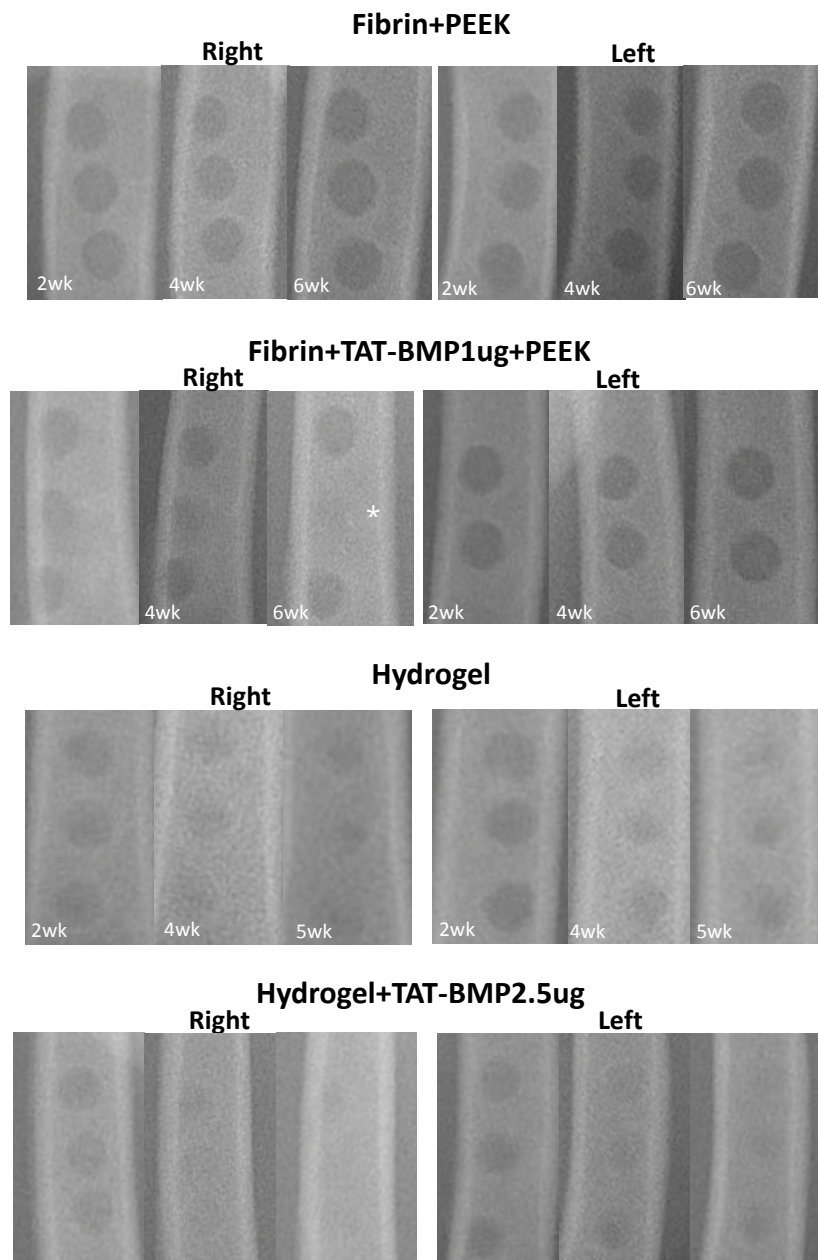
Follow up radiographs. Decreased radiolucency means occurrence of bone regeneration. As there were no materials inserted at astronaut indicated region, the defect was excluded in analysis.
